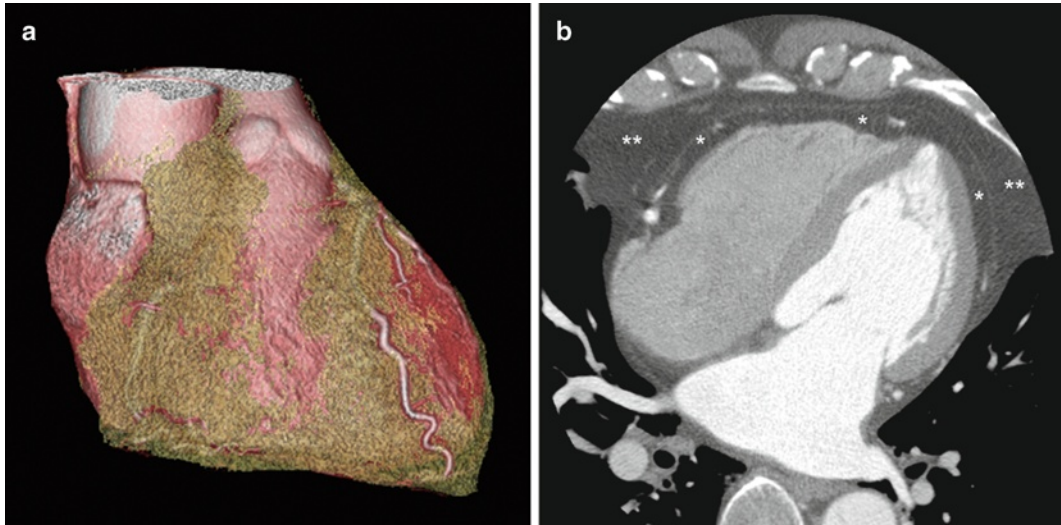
Computed tomographic images of epicardial adipose tissue. (a) A three-dimensional volume-rendered computed tomographic image showing the distribution of epicardial adipose tissue around the heart. Epicardial adipose tissue is primarily concentrated in the atrio-ventricular and inter-ventricular grooves along the major branches of the coronary arteries. (b) Epicardial and paracardial adipose tissues are separated by the parietal pericardium. *Single asterisk mark (*)* denotes epicardial adipose tissue and *double asterisk mark ()* denotes paracardial adipose tissue
